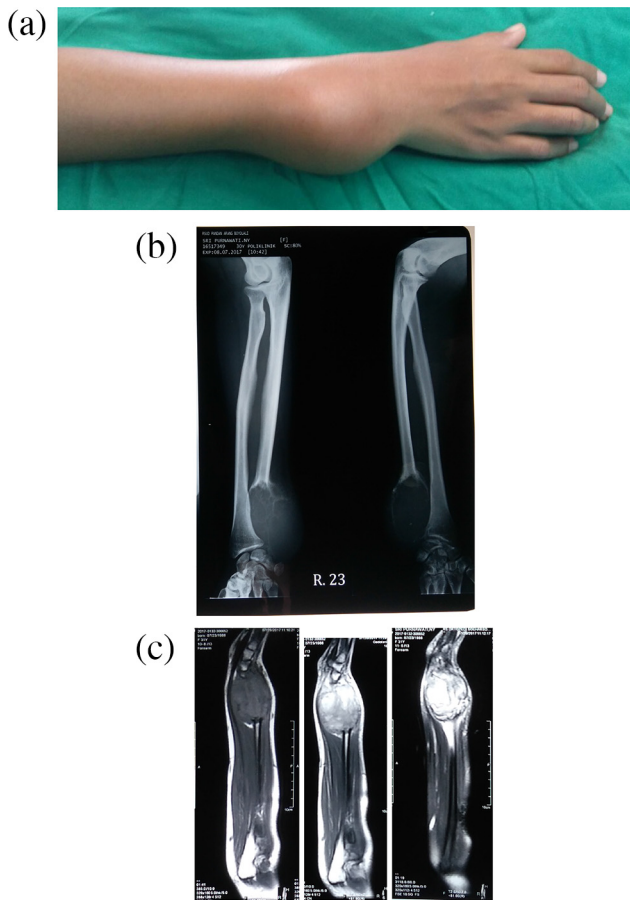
a) Clinical appearance lump on left wrist (case 2). b) pre-op AP Radiograph of the left wrist (Case 2). c) MRI examination of Case 2.
